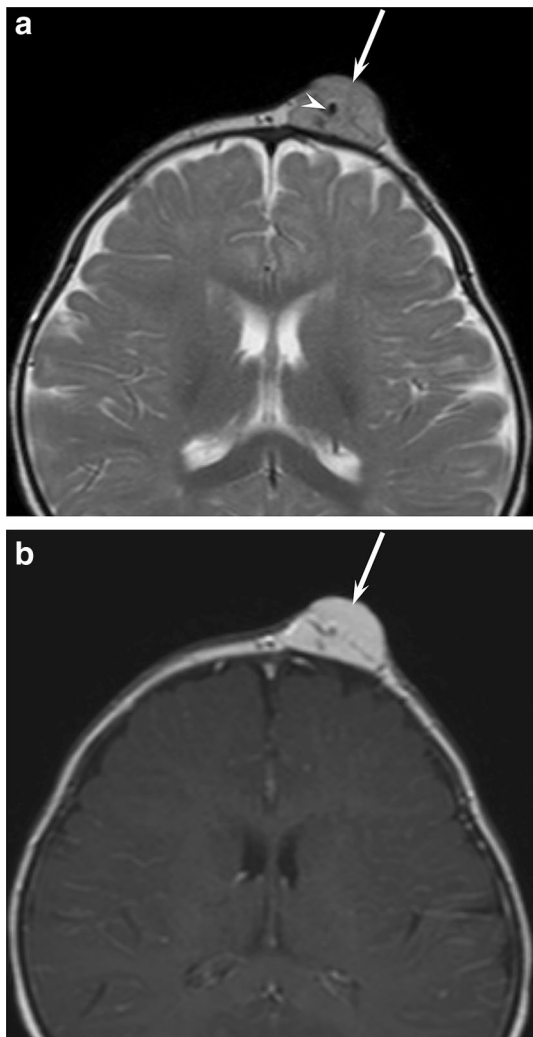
A 9-month-old boy with infantile hemangioma. a T2-weighted image shows a well-demarcated, heterogeneously hyperintense, subcutaneous lesion (arrow) with flow void (arrow head). b Fat-suppressed contrast-enhanced T1-weighted image shows homogeneously intense enhancement (arrow)
